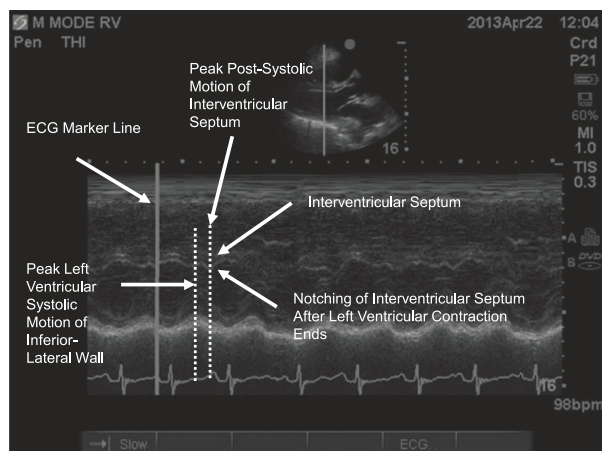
M-mode interrogation of the interventricular septum in a patient with right ventricular dysfunction and paradoxical septal motion. The M-mode interrogation line is placed through the middle of the interventricular septum in the parasternal long-axis view. As left ventricular contraction ends, there is posterior movement of the interventricular septum toward the left ventricular cavity. This appears as a bounce during two-dimensional echocardiography and represents paradoxical septal motion. RV = right ventricle.
